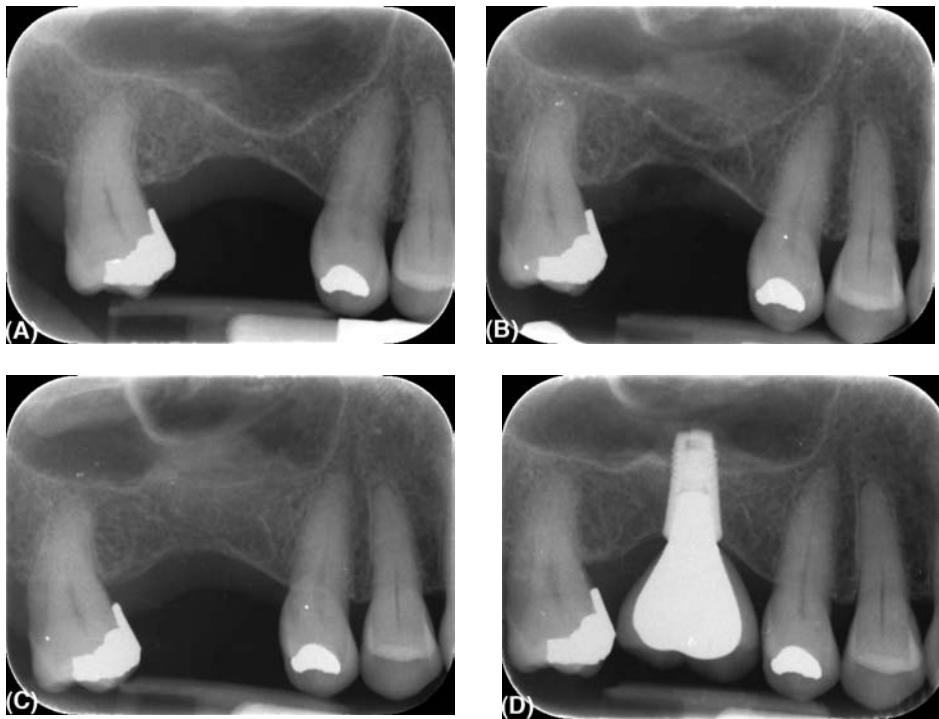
(A) Radiograph of a maxillary first molar space showing insufficient bone due to an enlarged maxillary sinus. (B) Radiograph immediately following bone grafting using a lateral window approach to the sinus. (C) Healing of the sinus bone graft after a period of four months. (D) Completed molar restoration using an Astra Tech 5-mm-diameter implant and a single-piece screw-retained crown.
